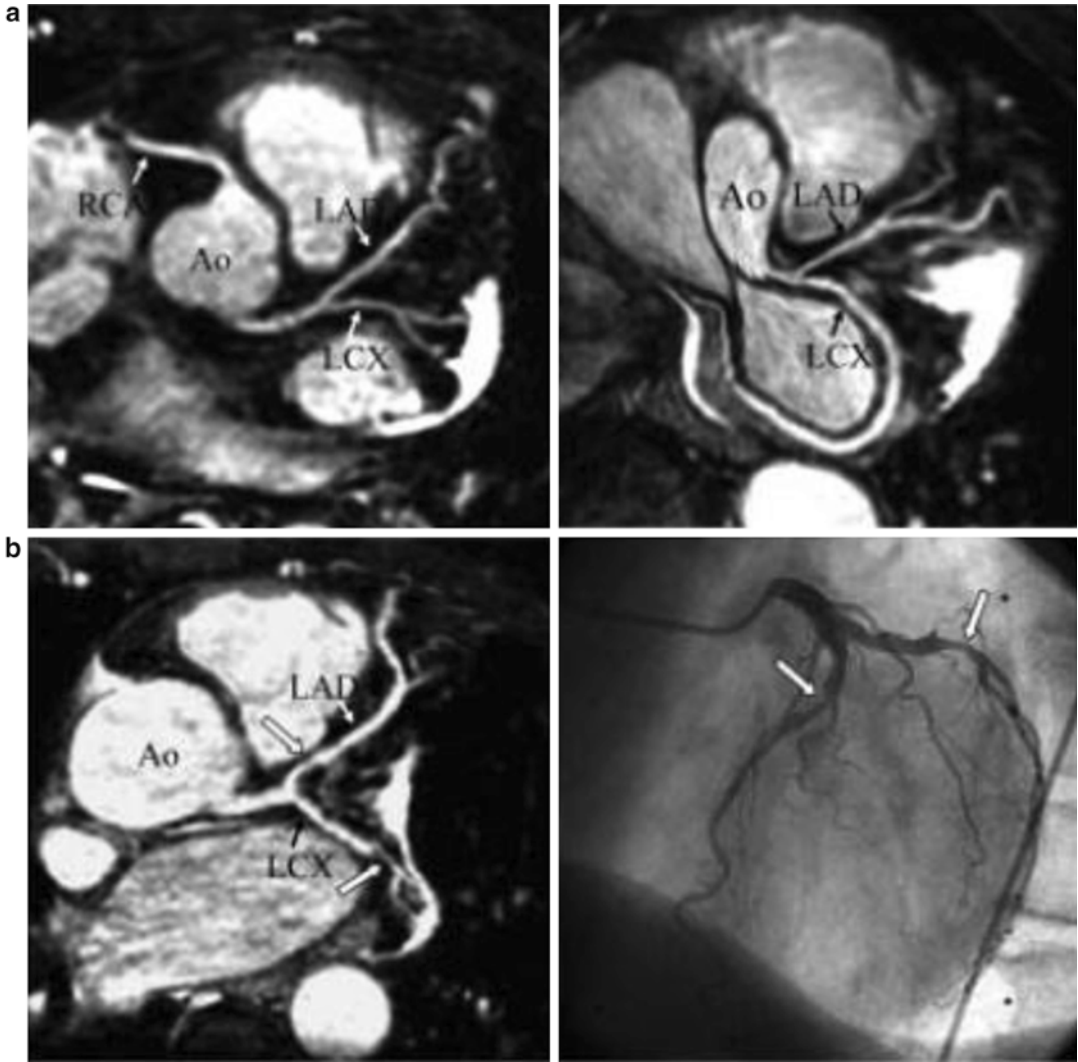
(a) Multiplanar reformatted MRCA images of right and left coronary arteries with excellent visualisation of left anterior descending artery (LAD) and left circumflex artery (LCx) with their side branches. Ao Aorta, RCA right coronary artery (b) MRCA of patient with two-vessel disease (left) in comparison with X-ray coronary angiography
